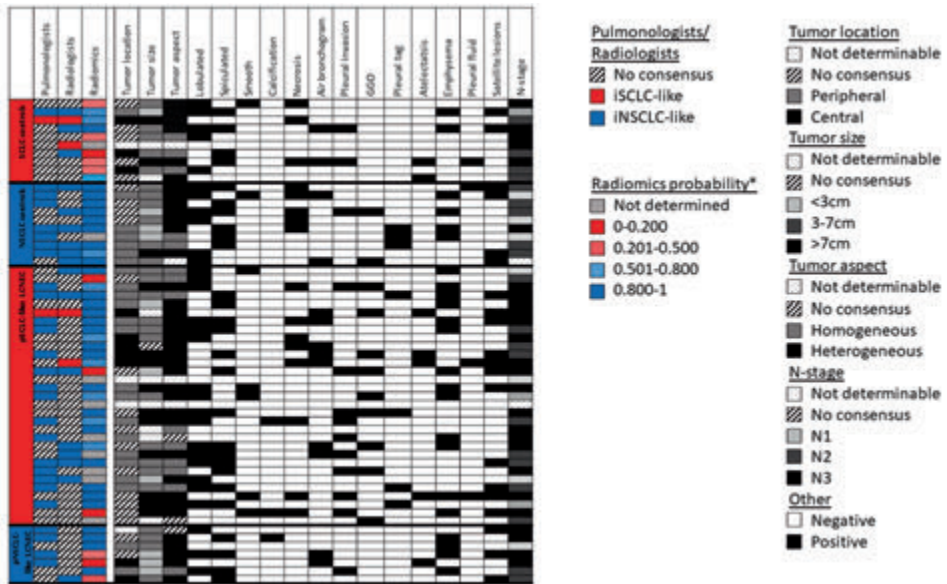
Clinical interpretation of CT-scans by pulmonary oncologists and radiologists, probability score of radiomics signature and semantic features of subtypes of stage IV large cell neuroendocrine carcinoma and control scans of small cell lung carcinoma and non-small cell lung carcinoma. *Radiomics probability: Close to 0 more likely to be SCLC, close to 1 more likely to be NSCLC. Abbreviations: SCLC = small cell lung carcinoma, NSCLC = non-small cell lung carcinoma, LCNEC = large cell neuroendocrine carcinoma, pSCLC-like = pathological SCLC-like, pNSCLC-like = pathological NSCLC-like, iSCLC-like = imaging SCLC-like, iNSCLC-like = imaging NSCLC-like, GGO = ground glass opacities, N-stage = nodal stage.
